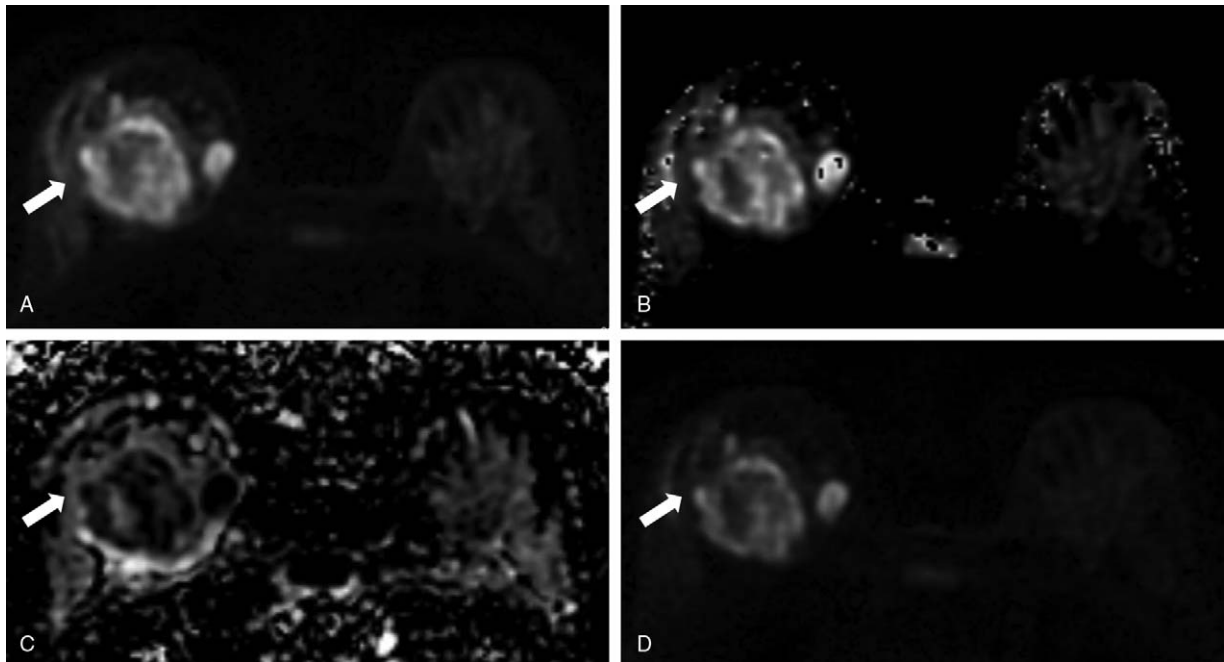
Images of a 24-year-old woman with invasive ductal breast carcinoma in right breast. (A) DWI with $b=800\text{ s/mm}^2$; (B) b-value map; (C) ADC map; and (D) optimal cDWI ($b=1200\text{ s/mm}^2$). Both the b-value map and optimal cDWI show the striking contrast between the lesion and the surrounding fibroglandular tissue. ADC=apparent diffusion coefficient, cDWI=computed DWI, DWI=diffusion-weighted imaging.
